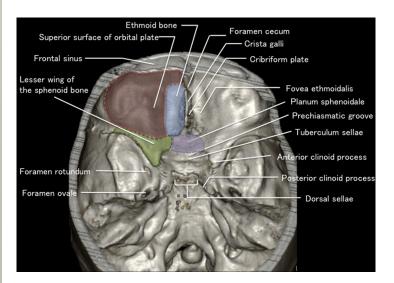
Anatomy of the anterior skull base. Volume rendering CT image of the skull base demonstrates an overview of the anterior cranial fossa.
